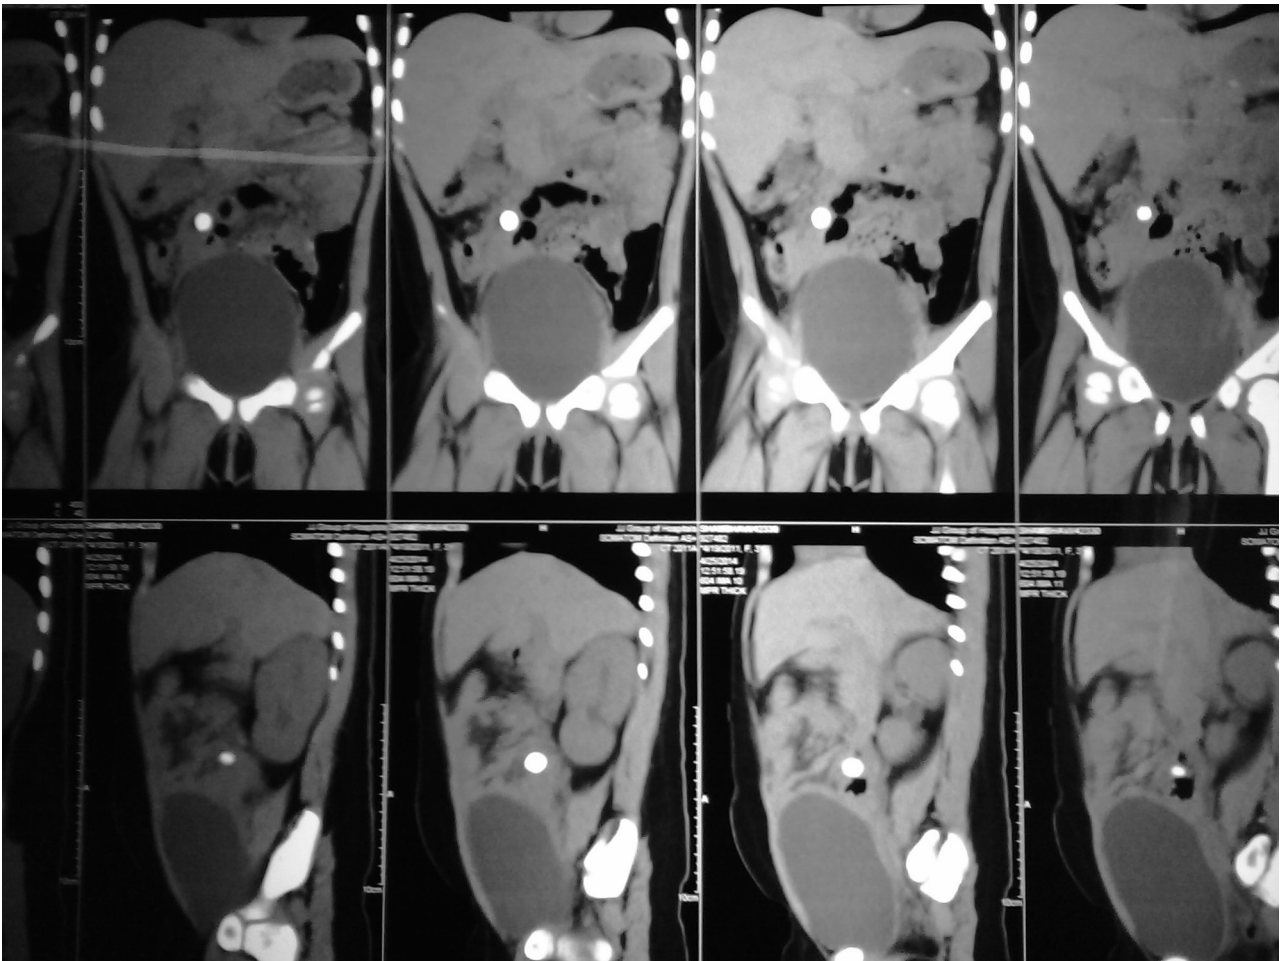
CT abdomen and pelvis showing spherical foreign body.
